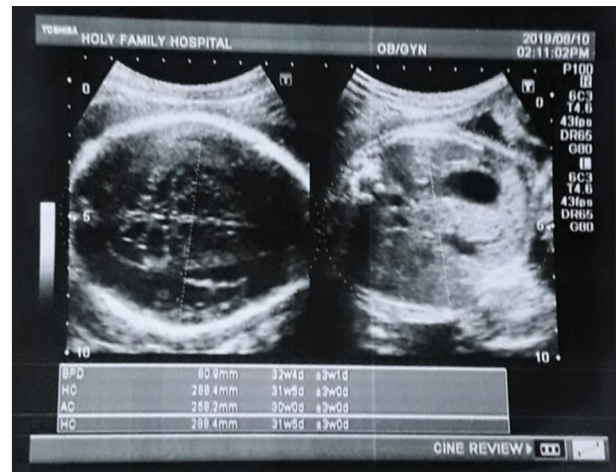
Sonogram of fetal head and abdomen
